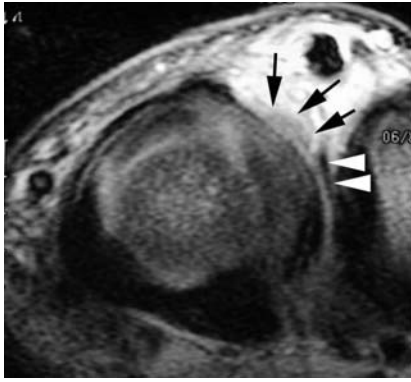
“Pseudo-Stener” lesion of the radial collateral ligament of the fifth right MCP joint. Axial T1-weighted (600/24) contrast-enhanced image of the extended joint. Note the round proximally retracted ligament (*arrows*) overlying the sagittal band (*arrowheads*)
